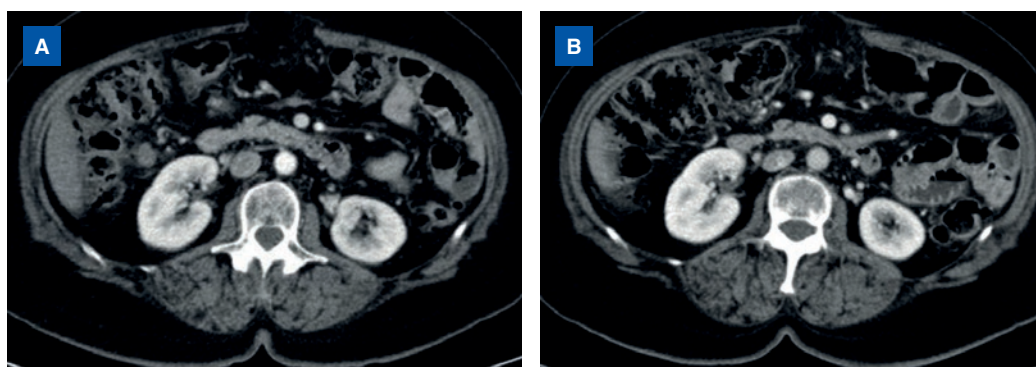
CT scan of the thorax, abdomen, and pelvis. A: October 2019: progression with olaparib. B: March 2020: following four cycles of trabectedin + PLD.
